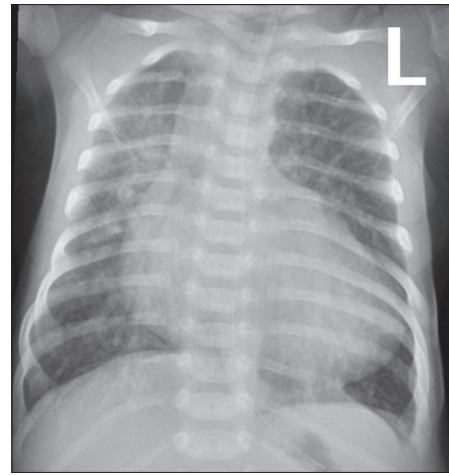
Chest X-ray showing egg-on-stick appearance and a narrow mediastinum
